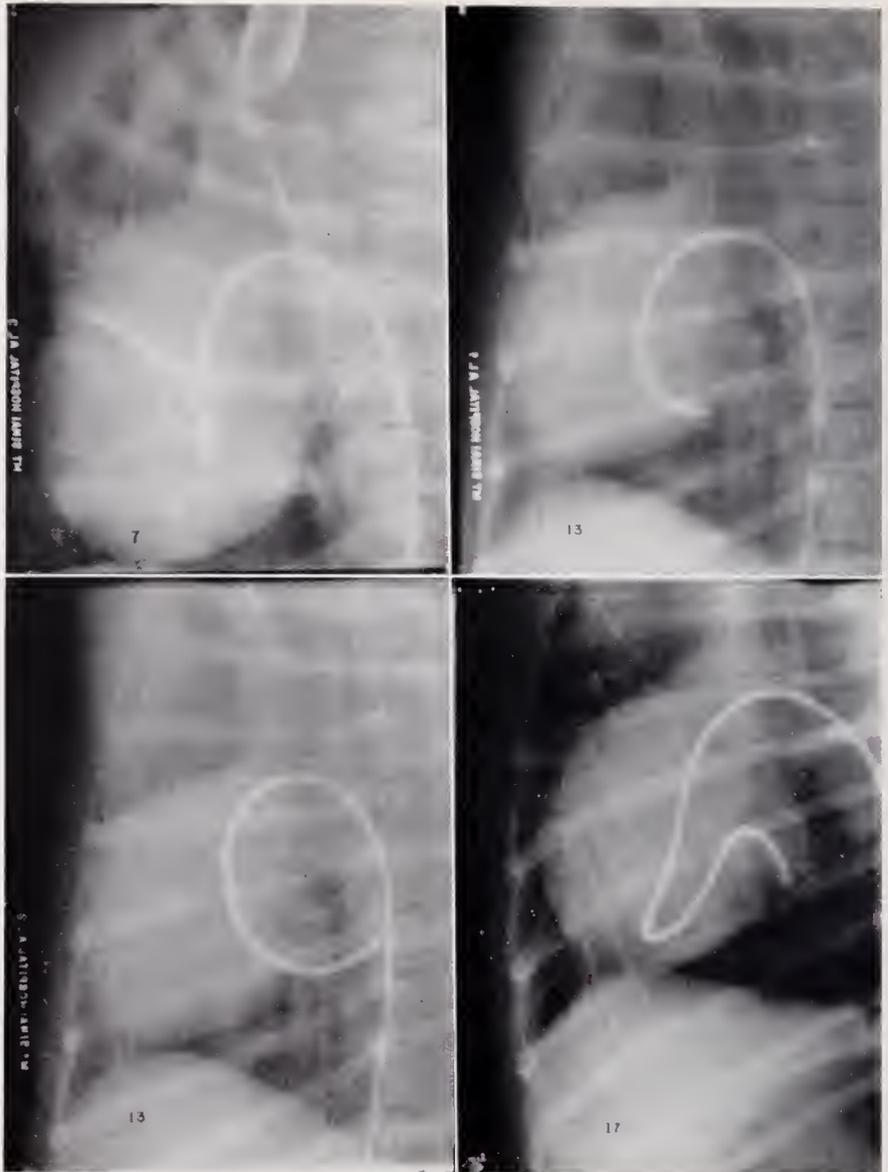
Four other "spot" x-ray films. (*7—catheter tip probably in a right pulmonary vein; *13 (upper)—left atrium; *13 (lower)—pulmonary vein; *17—left atrium or pulmonary vein.)
